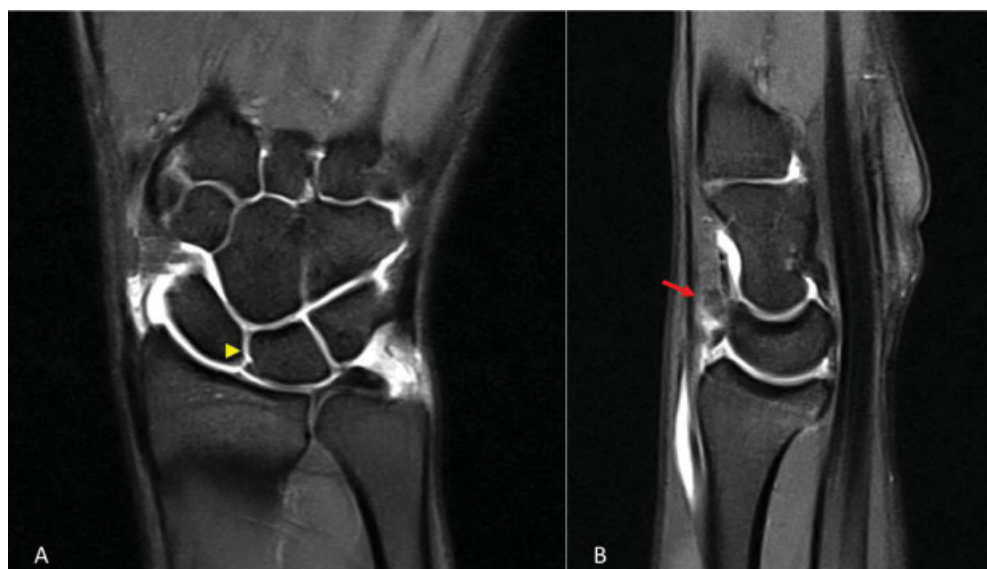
MR arthrogram of the wrist with coronal (A) and sagittal (B) T2-weighted sequences, arrowhead indicating partial scapholunate tear, arrow indicating dorsal wrist mass.
